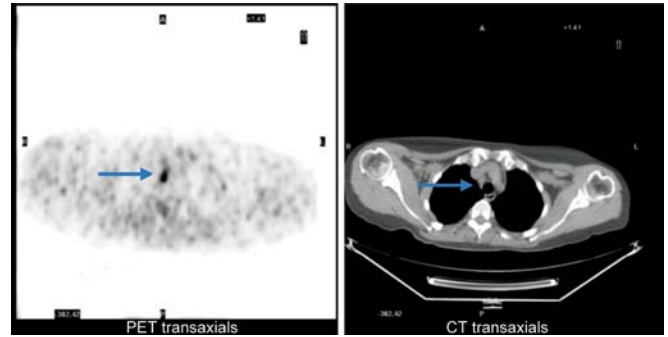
Transaxial thoracic 18F-FDG CT and PET images of the patient
